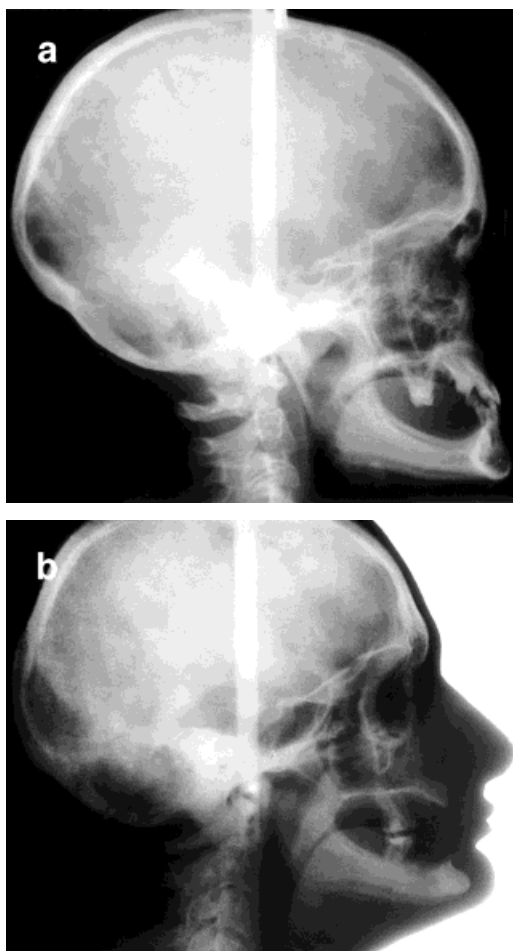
Typical radiographs of patients suffering from HED. a: Clinically diagnosed hypodontia with the absence of 28 permanent teeth (patient age, 21 years), but without any systemic defects. b: The second patient (age 23) has 29 missing teeth but has the clinical signs of syndromic hypohidrotic ectodermal dysplasia.
